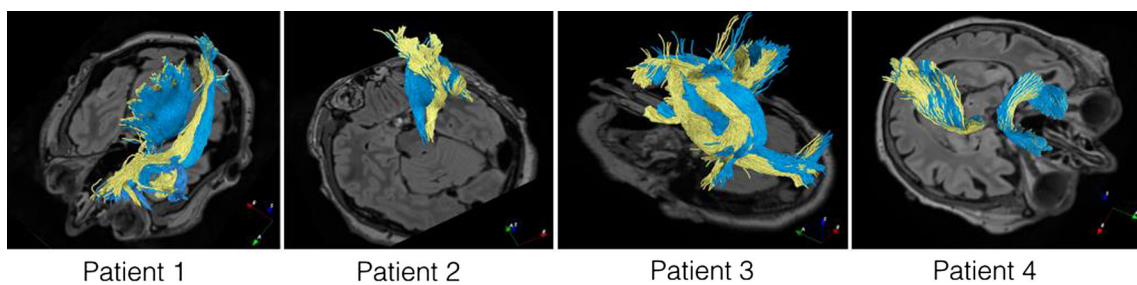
Demonstration of tractography deformation for the major white matter fiber bundles. Tracts before and after deformation are shown in yellow and blue colors. Axial T2 FLAIR MRI slices are added to help locate the tracts
